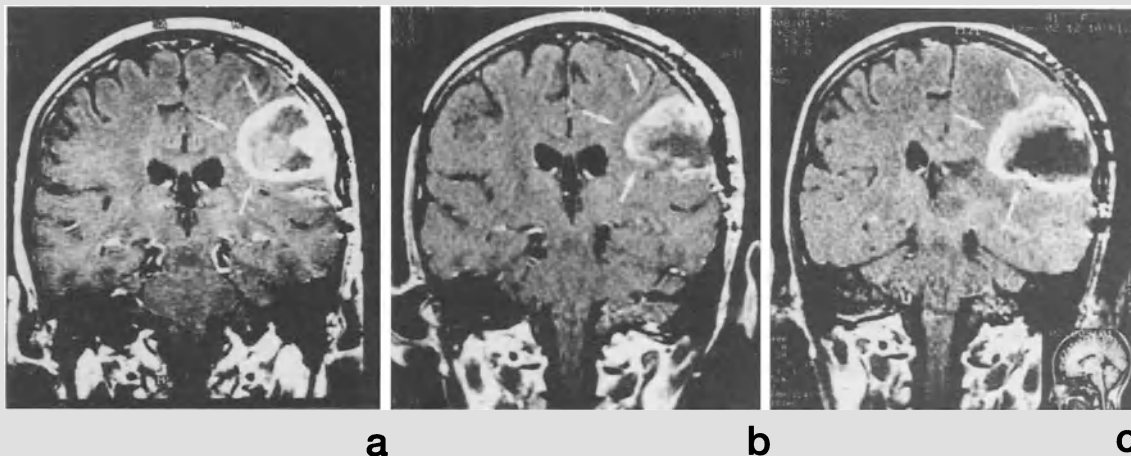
Magnetic resonance imaging before and after gene therapy. Axial contrast enhanced T1W1 image of a large recurrent glioblastoma, (a) before partial resection and MPC injection, (b) after reoperation, (c) after one dose of gene therapy, showing a large necrotic area and persistent residual tumour (arrows)
